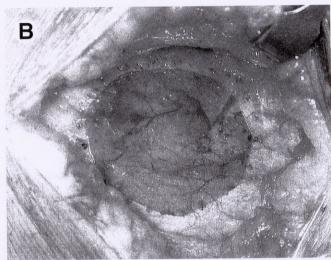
(A) Defect dimensions are measured and documented by using a sterile ruler. (B) A template of the defect is made by placing a sterile tracing material (ie, sterile transparent x-ray film) over the defect and outlining the defect with a marking pen. The template is cut and used during periosteal patch procurement.
